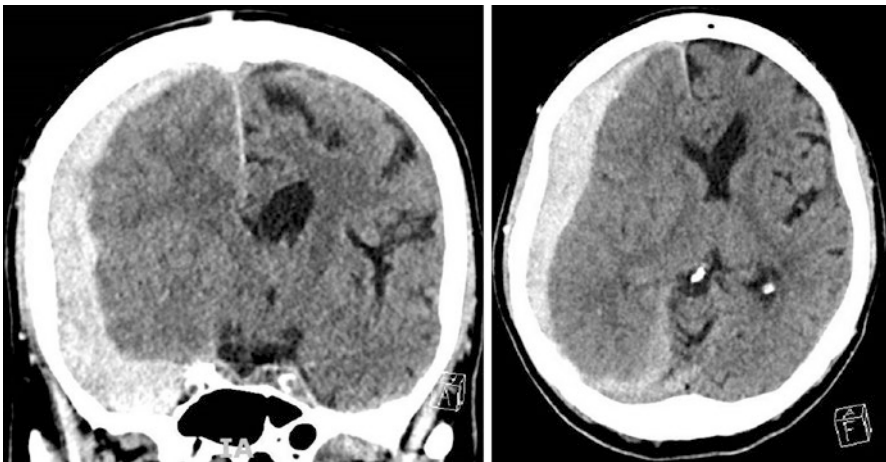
CT scan demonstrating a large, acute right sided subdural hematoma causing sulcal and cisternal effacement with significant midline shift in a patient who fell
